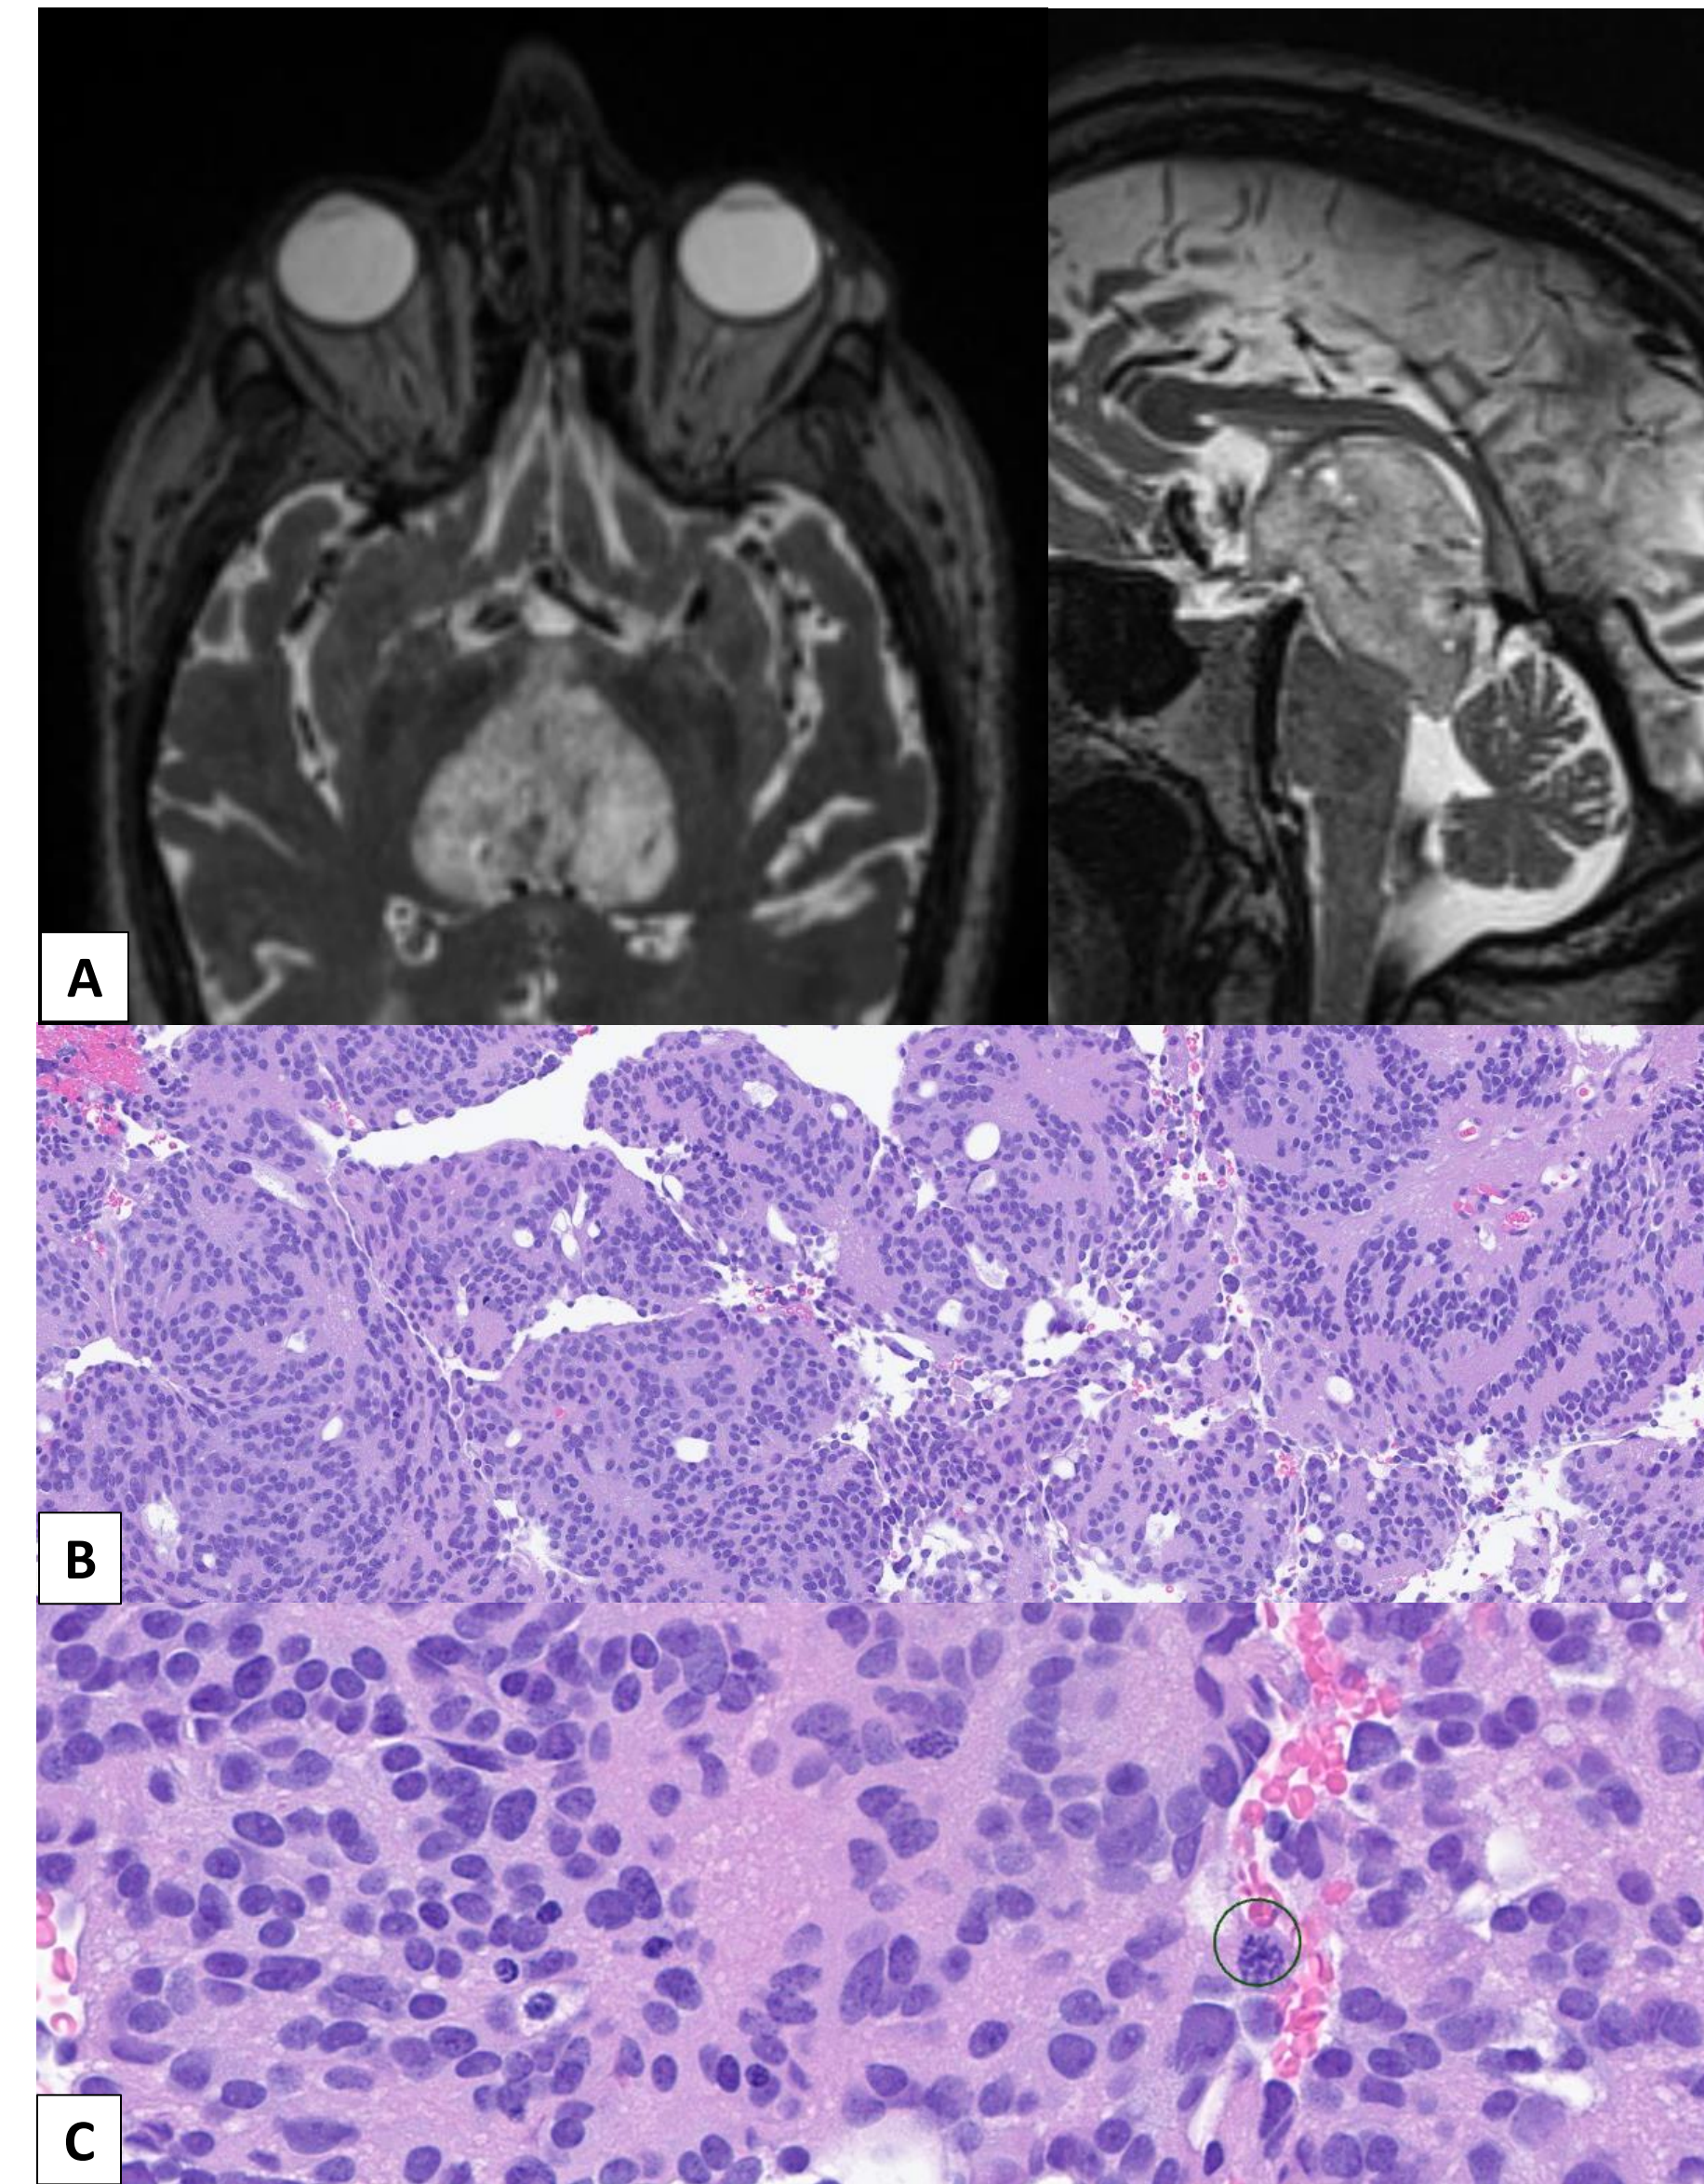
A) MRI showing axial and sagittal views of T2 hyperintense pineal region mass, B) pineocytoma with large rosettes (10x), C) Pineocytoma with up to 5 mitosis/10hpf (40x, circled mitosis), D) CNV plot obtained from NIH/NCI DNA methylation profiling.
